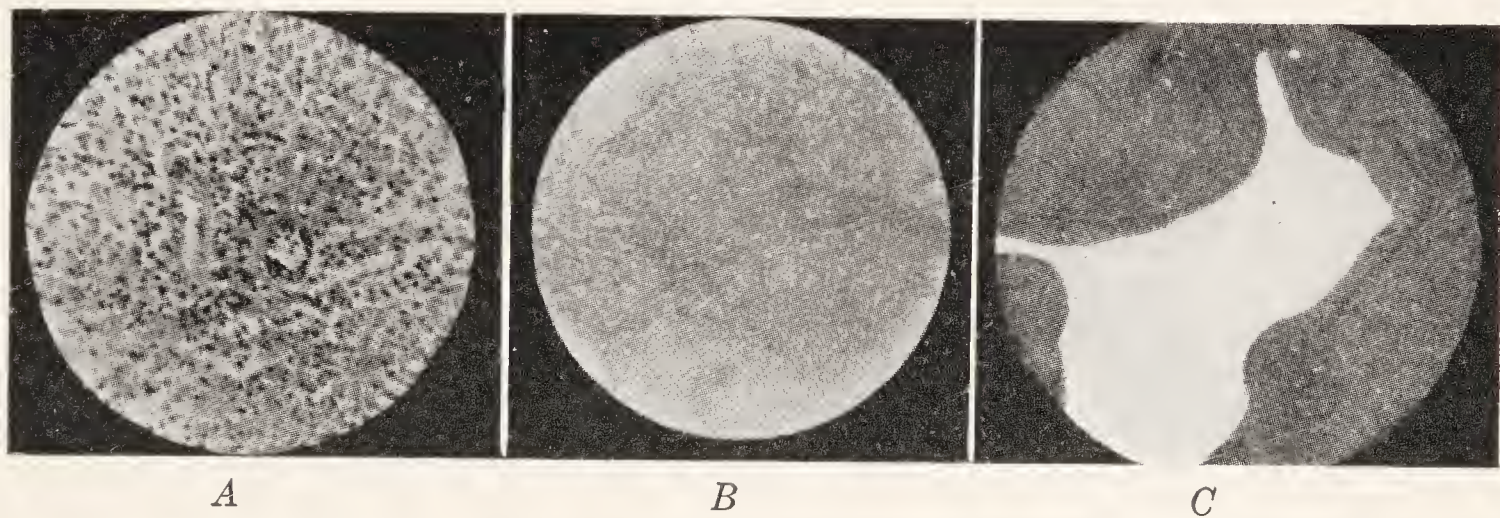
A, Chronic type of periapical inflammation. Preponderance of small, round cells. Capillary blood vessels are seen, establishing a connection between the focus of infection and the general circulation. B, Masses of squamous epithelial cells (*débris épithéliaux paradentaires*) embedded in chronic periapical inflammatory tissue. C, Early stages of cyst formation, showing cavity lined with several layers of epithelium, with chronic inflammatory tissue at the periphery. (Blair and Ivy.)
